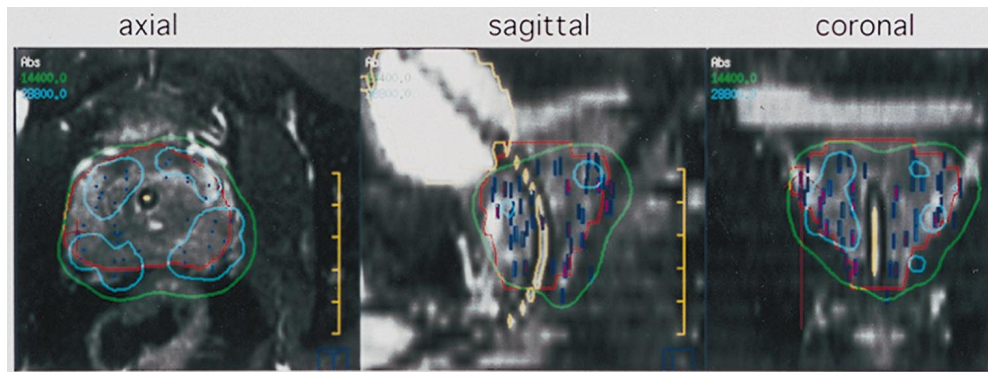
Fusion images. Isodose distributions from CT localization of implanted seeds are displayed on MR images. In patients being treated with ^{125}I seeds alone our goal is to deliver a minimum of 144 Gy (green isodose line) to the prostate and to keep the dose to the urethra below 288 Gy (light blue isodose line). Implant quality is evaluated qualitatively by paging through axial, sagittal, and coronal images while looking for areas where the prostate (red line) is not covered by the prescription isodose as well as areas where the 288 Gy isodose touches the urethra. In the case shown in this figure, 95% of the prostate received at least 144 Gy and maximum urethral dose is less than 288 Gy (dose-volume histogram calculations).
